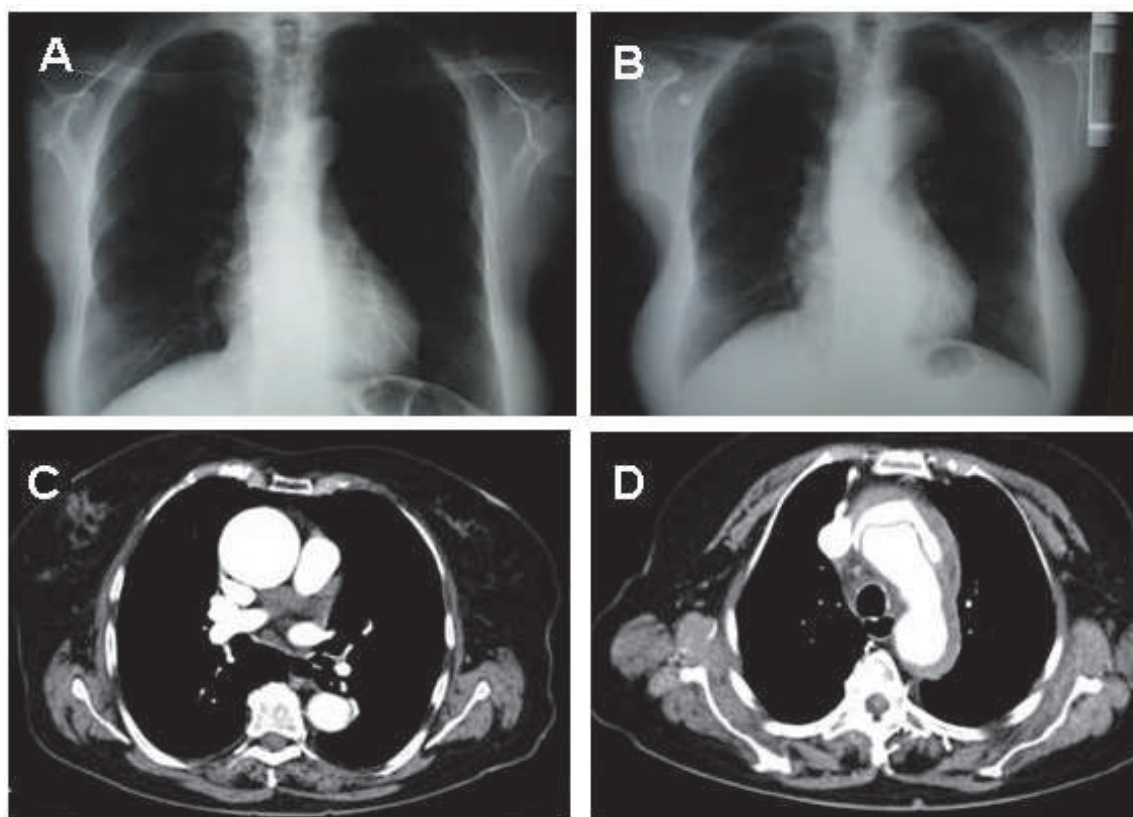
(A) Chest x-ray of a 68 -years old woman at the time of GCA diagnosis. (B) Four years later the chest radiograph of the same patient showed mediastinum broadening and aortic aneurysm was confirmed by CT-scan. (C) CT scan of another patient with GCA demonstrating an aneurysm with a maximum diameter of 5 cm at the ascending thoracic aorta. (D) Aortic dissection at the ascending aortic segment in a patient with GCA presenting with chest pain.
